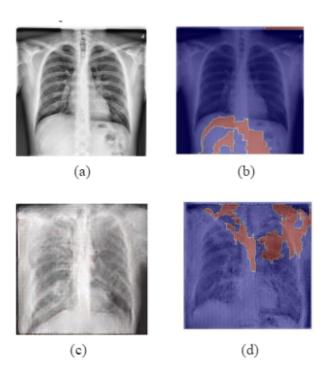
(a) Normal Lung X-ray
